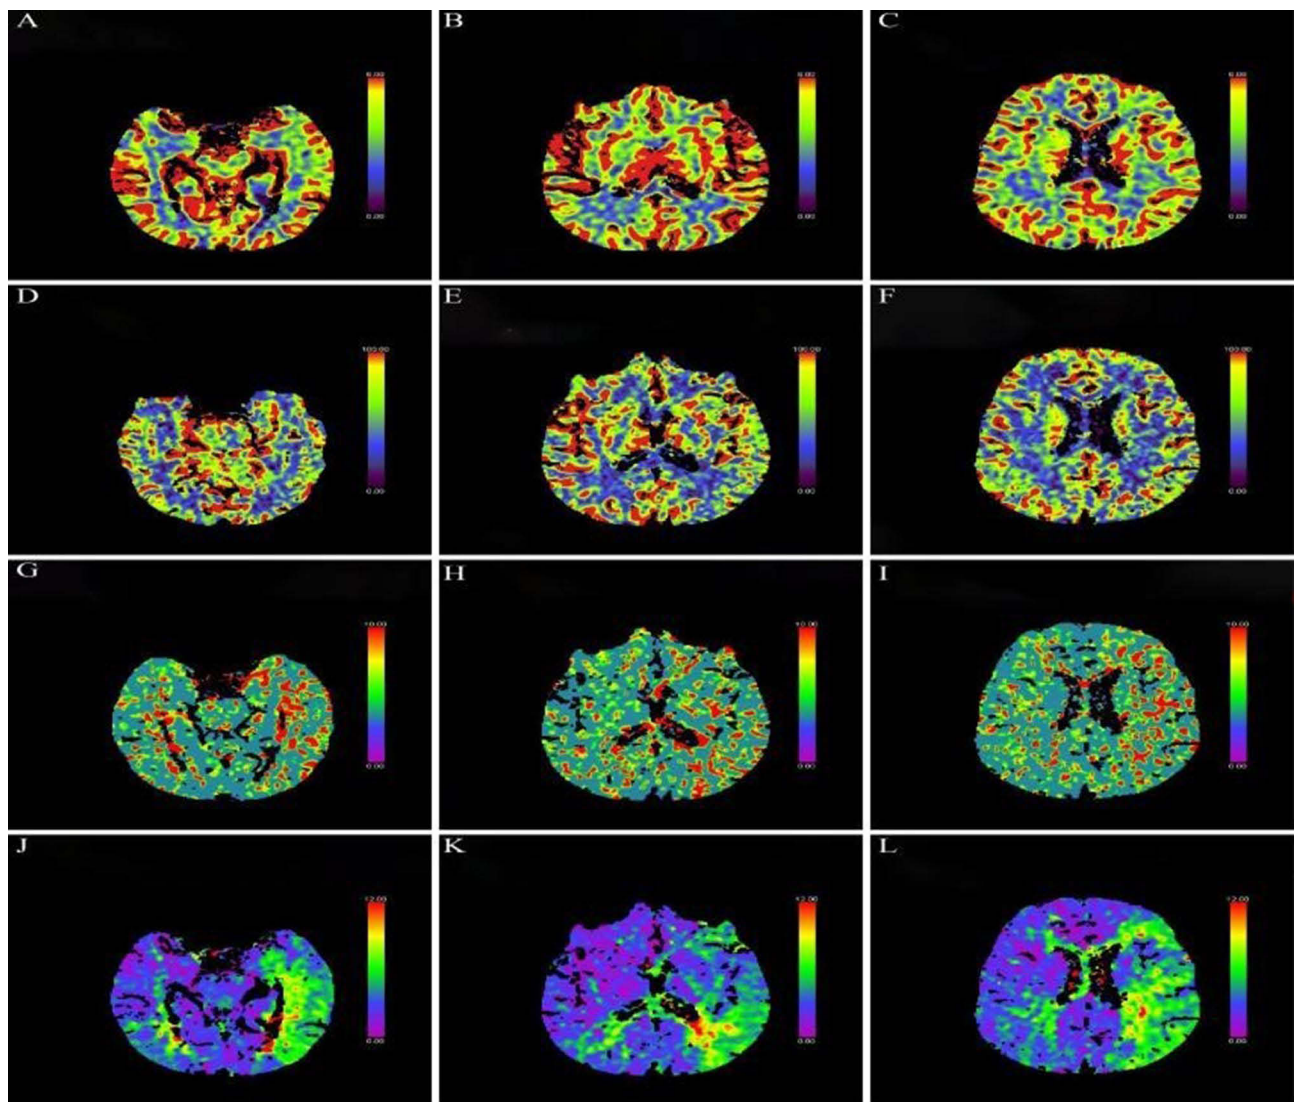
Representative case. Preoperative computed tomography perfusion (CTP) imaging of a 65-year-old male patient with repeated weakness of the right limb for more than 2 months. The cerebral blood volume (CBV) of bilateral cerebral hemispheres is equivalent (A–C), the cerebral blood flow (CBF) of bilateral cerebral hemispheres is equivalent (D–F), the mean transit time (MTT) of the left cerebral hemisphere is longer than that of the right (G–I), and the time to top (T-Max) of the left cerebral hemisphere is longer than that of the right (J–L).
